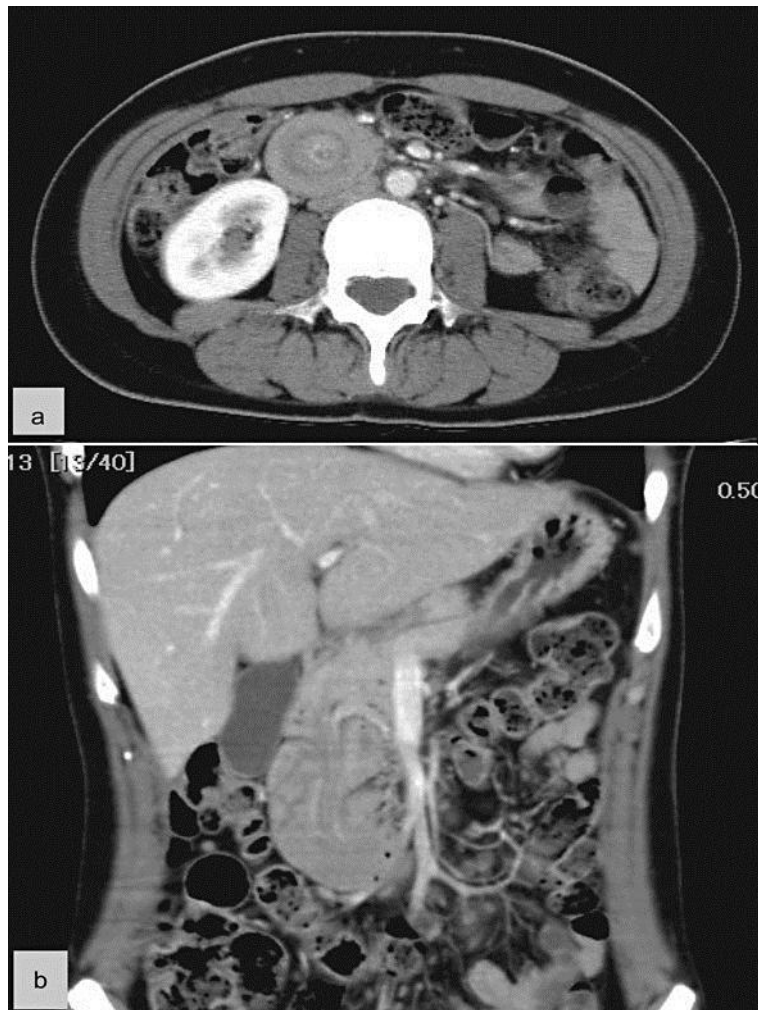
Subsequent contrast-enhanced abdominal CT shows ‘target’ appearance in the region of the duodenum confirming the diagnosis of duodenoduodenal intussusception (a). Coronal multiplanar reformatted image shows duodenoduodenal intussusception (b).
